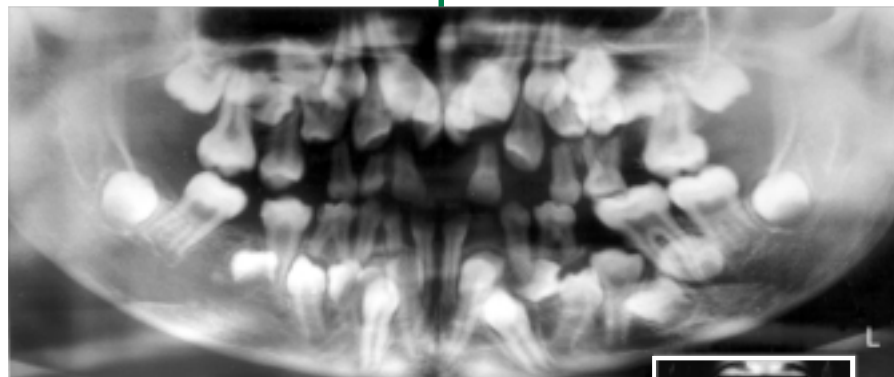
Cleidocranial dysplasia is associated with multiple supernumerary teeth (panoramic radiograph). Affected patients often have hypoplastic or absent clavicles and have the flexibility to bring their shoulders close together in the midline (e.g. photograph).
